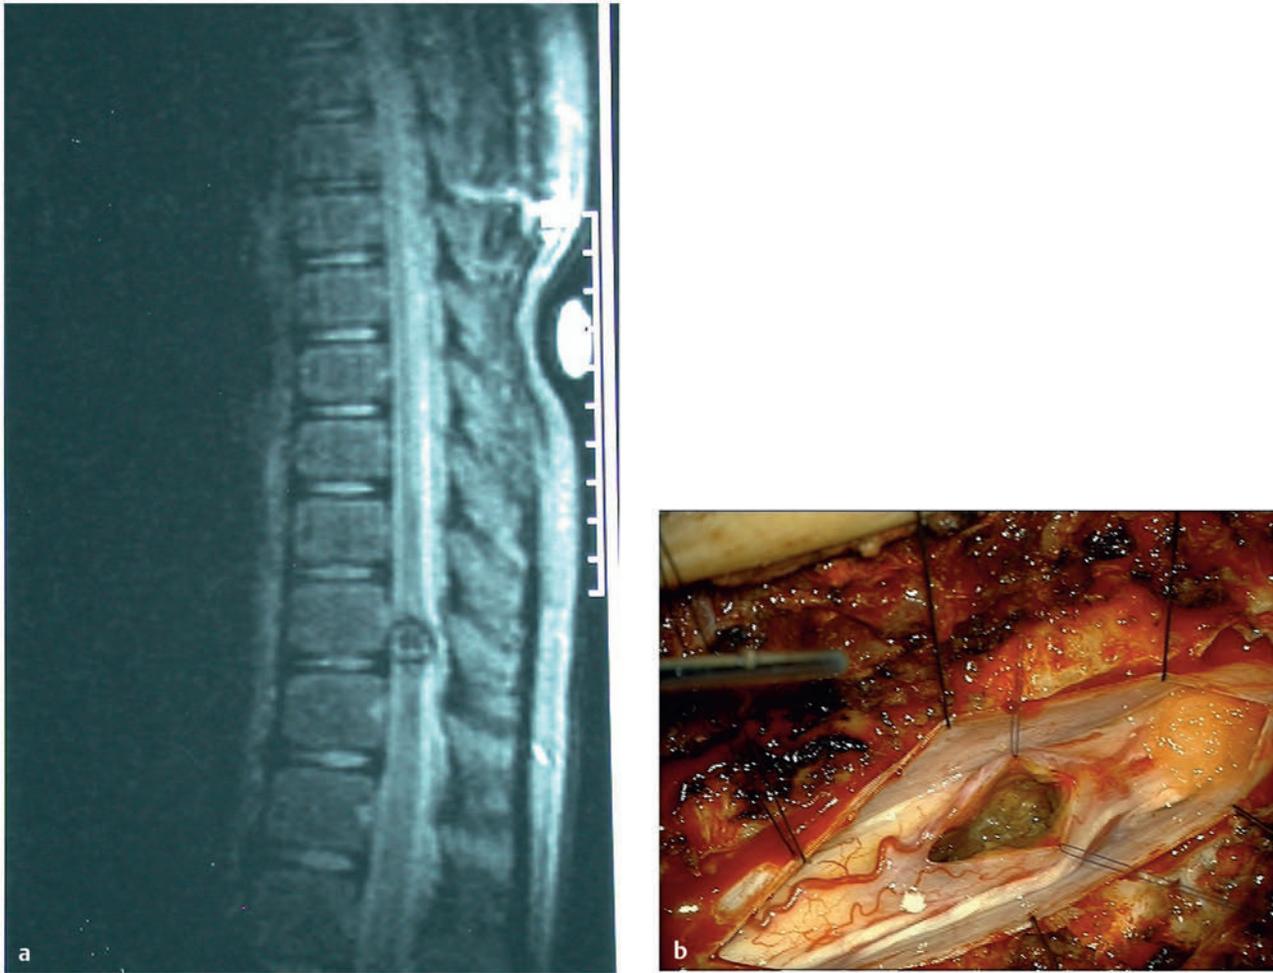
(a) Magnetic resonance image of an intramedullary cavernous malformation (CM) in a young teenager. (b) Intraoperative image showing an intramedullary CM during resection.
